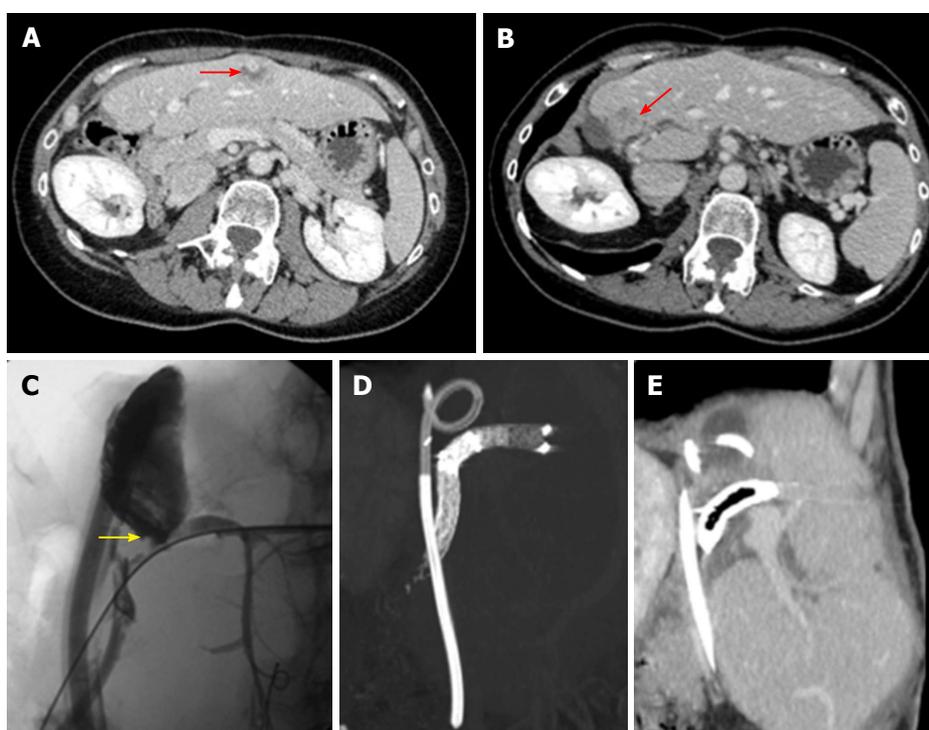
Recurrence appears with multidetector computed tomography and/or magnetic resonance imaging signs of the original tumor, though recurrence can manifest with pleomorphic, nonspecific appearance in our experience. A, B: Multifocal recurrent cholangiocarcinoma presenting 16 mo after right trisectionectomy associating liver partition and portal vein ligation for staged hepatectomy. Lesions showed atypical persistently hypovascular appearance on dynamic contrast-enhanced multidetector computed tomography; C-E: Wedge resection of recurrences was complicated by biliary leakage, as shown on percutaneous transhepatic cholangiography (arrow in C), treated by positioning a drainage within the biloma and a biliary stent graft, as shown on maximum intensity projection reconstruction in D and oblique sagittal reformation in E.
